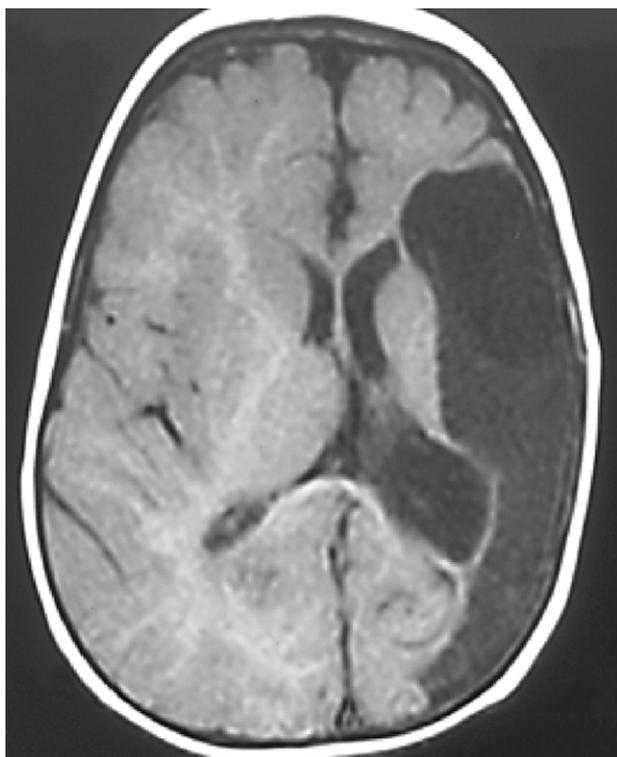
Axial MRI of 9-month-old child with evidence of perinatal stroke. Note the skull asymmetry as well as the large porencephalic cyst.
